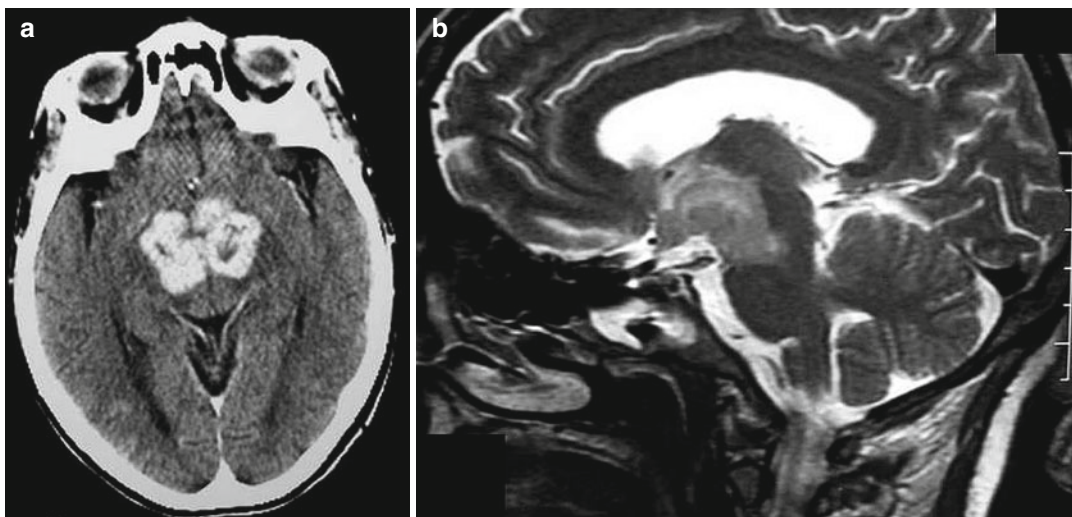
Enhanced CT scan on axial view (a) and sagittal T2-weighted MRI (b) showing a bilateral hypothalamic lymphoma with suprasellar extension, optic chiasm infiltration and brainstem involvement
